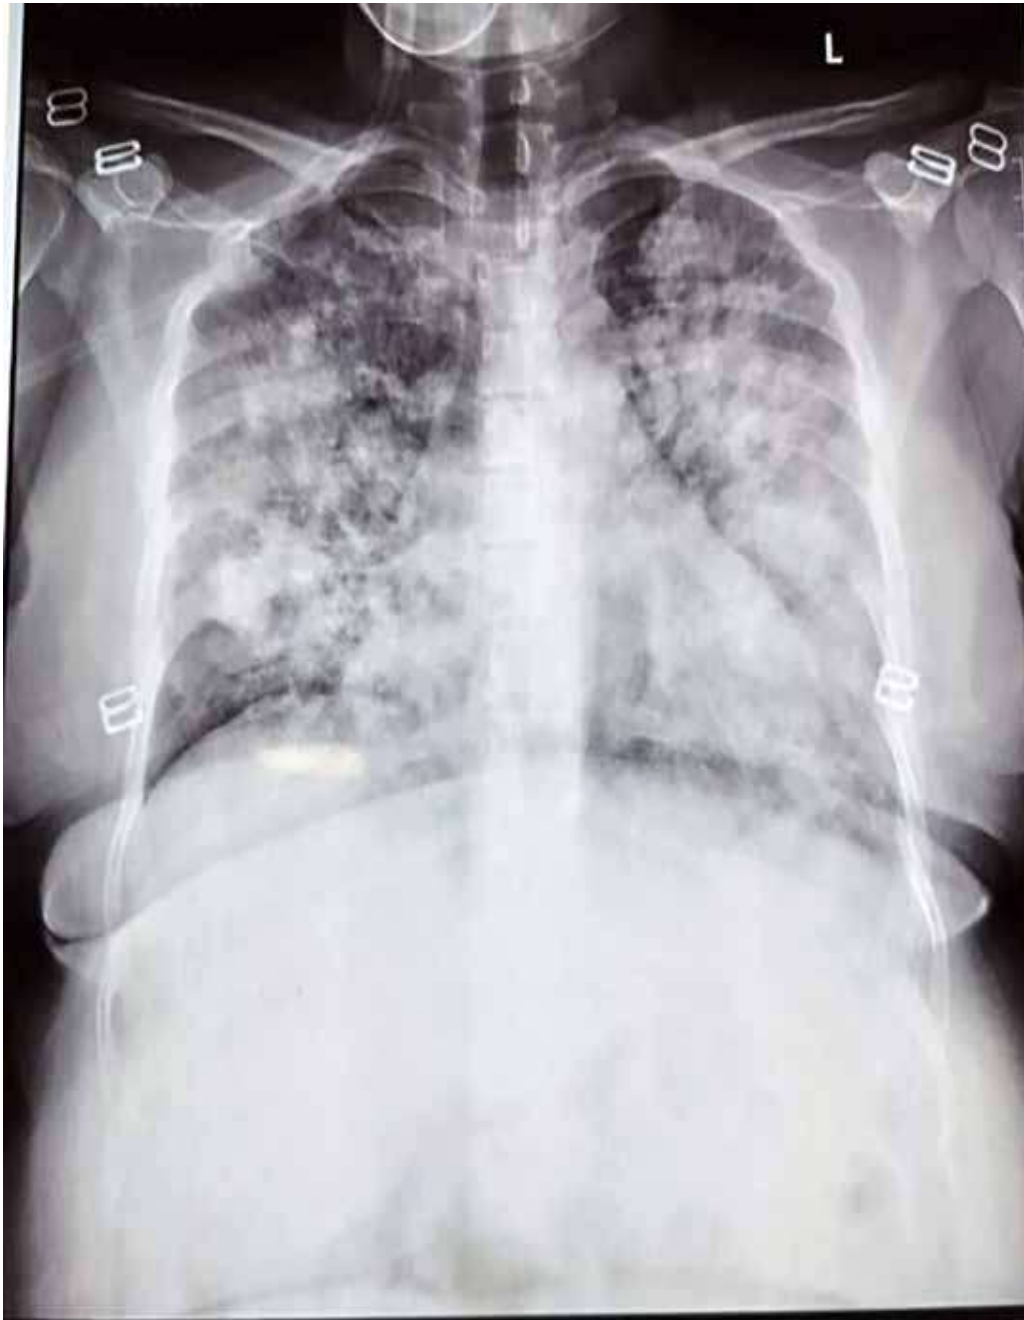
Chest X-ray showing bilateral dense heterogeneous infiltrates
